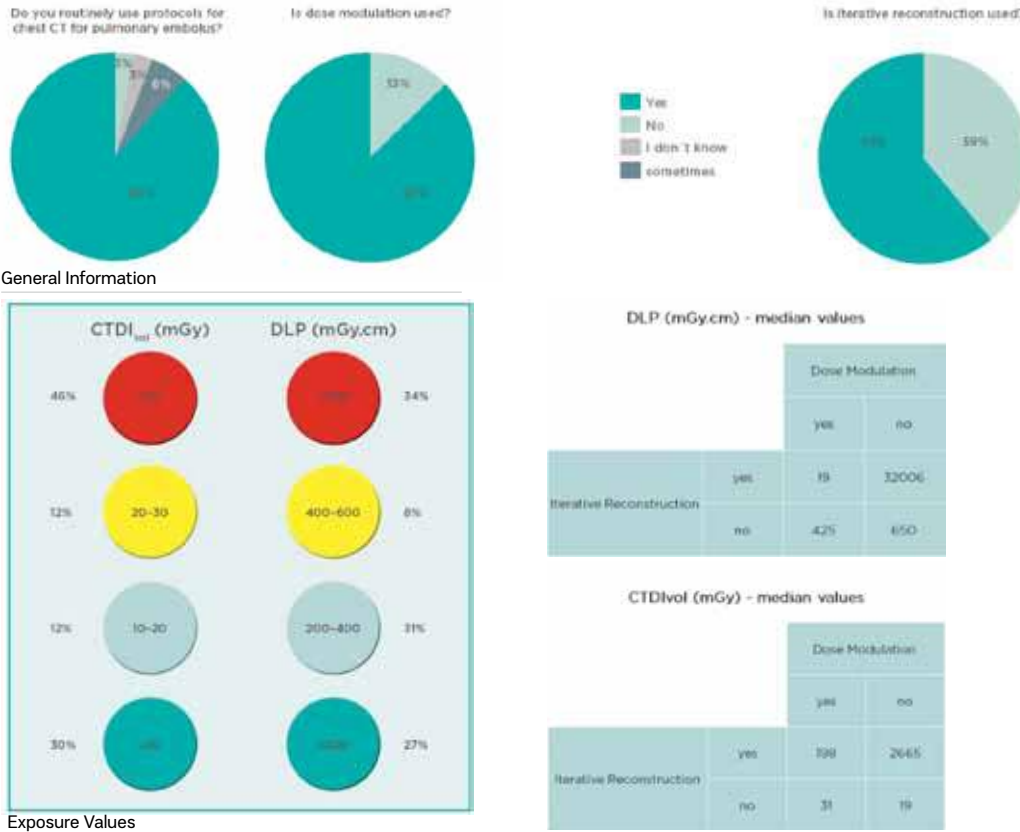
CT chest: pulmonary embolus - Preliminary results
